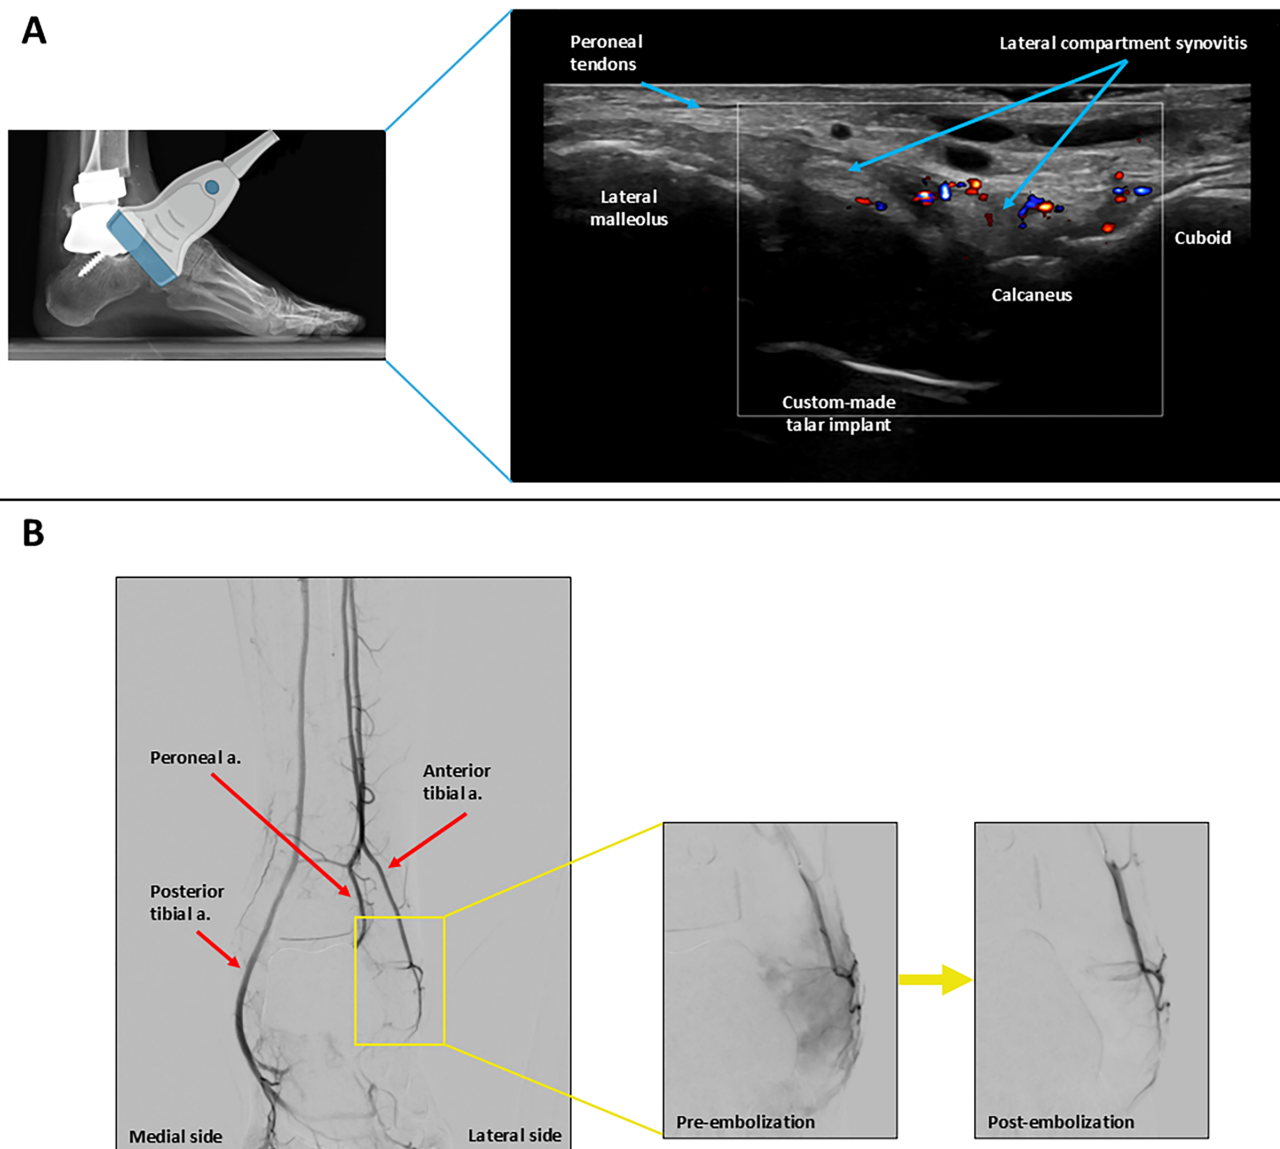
Ultrasound of the anterolateral left ankle demonstrating grade 2 synovial hypertrophy and grade 2 hypervascularity on color Doppler, consistent with active synovitis. Angiographic findings of the left ankle. (A) Baseline angiogram showing the distal tibial arterial vasculature. (B) Superselective catheterization of the malleolar branch of the anterior tibial artery revealing intense perimalleolar blush in the lateral compartment of the ankle. (C) Postembolization angiogram demonstrating near-complete disappearance of the abnormal perimalleolar blush.
